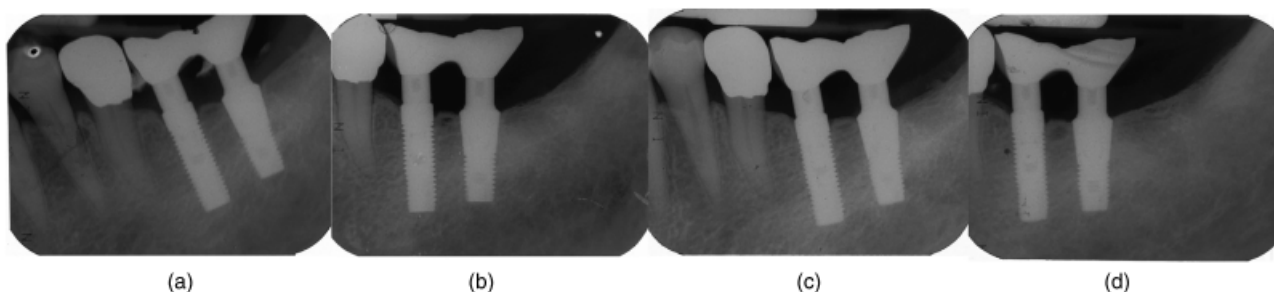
Intra-oral radiographs of implants (a: baseline; b: 1-year; c: 2-year; d: 3-year follow-up).
